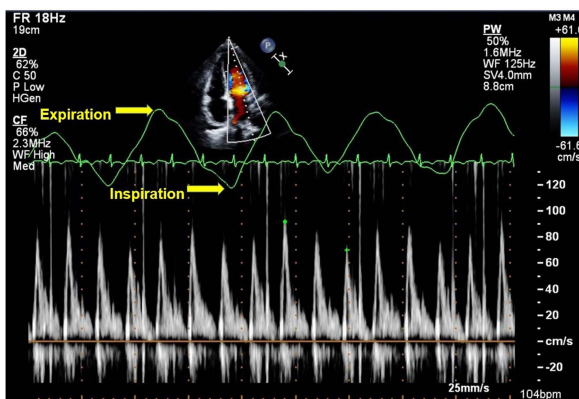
Transthoracic echo Doppler study across the mitral valve. Constrictive physiology demonstrated by Doppler study of mitral inflow. Difference in flow between inspiration and expiration is 24%, which is significant for constriction.
